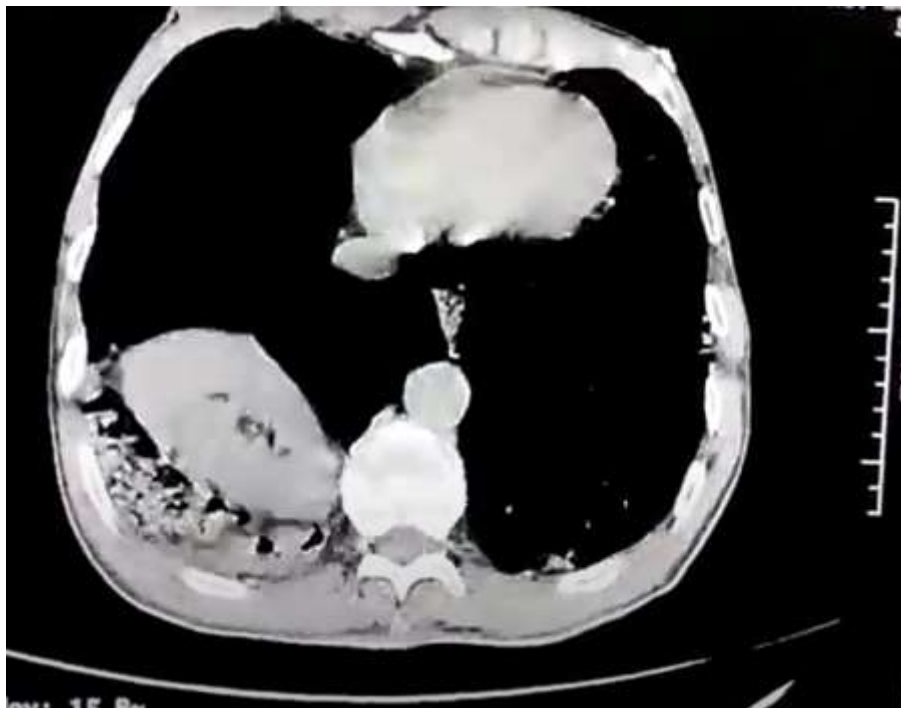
CT axial section showing the right kidney intra thoracically
